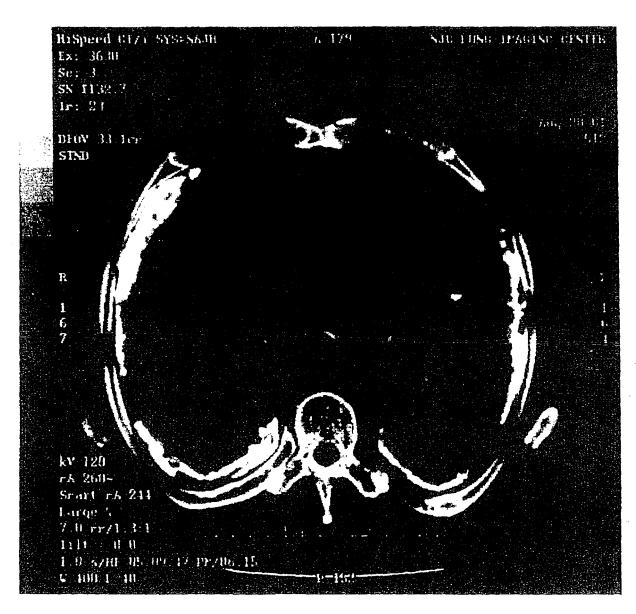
Chest CT depicting extensively calcified thick pleural rind extending around most of the circumference of the lung typical of diffuse pleural thickening.
